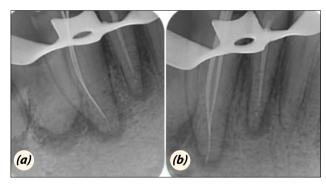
(a) Working length determination radiograph (b) Mastercone radiograph.
